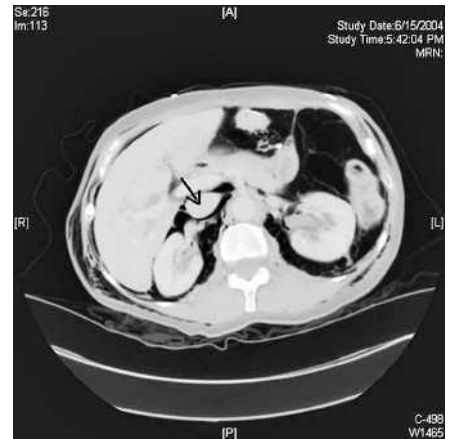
Abdominal computed tomography revealed that the patient had pneumoretroperitoneum, with air surrounding the inferior vena cava (arrow) and the right kidney.
